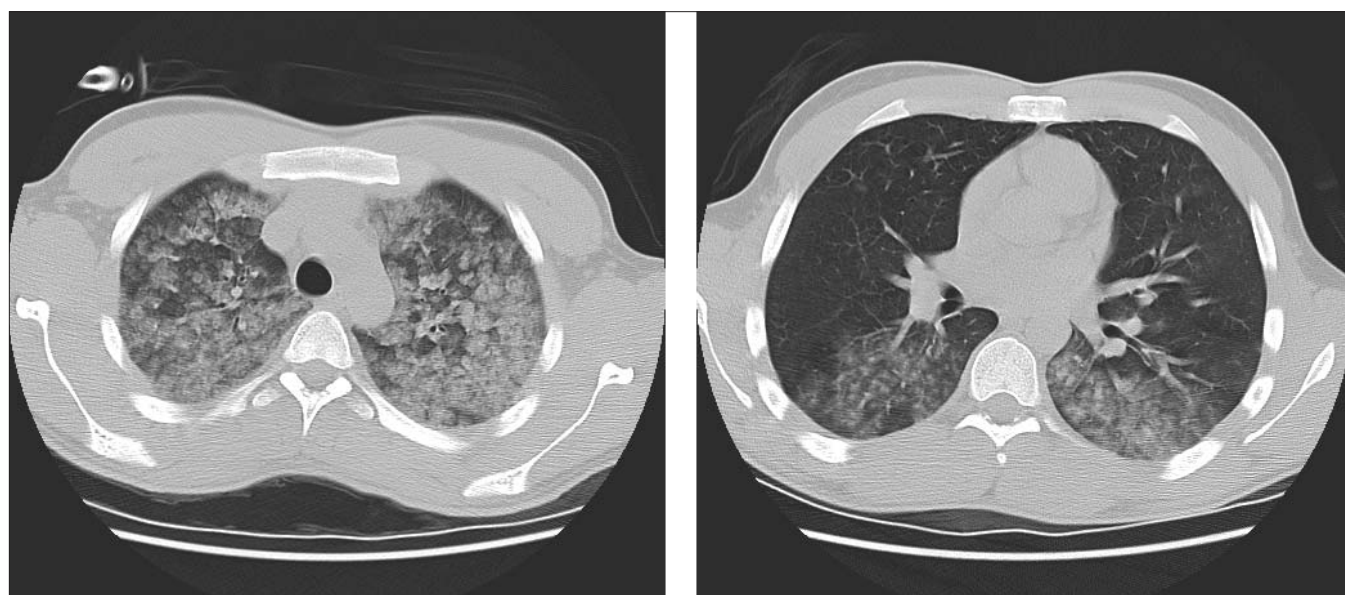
An unenhanced, high-resolution spiral CT scan of the chest (left and right) showing symmetrical, predominantly apical upper lobe and posterior lower lobe, diffuse airspace findings with ground glass opacities.
